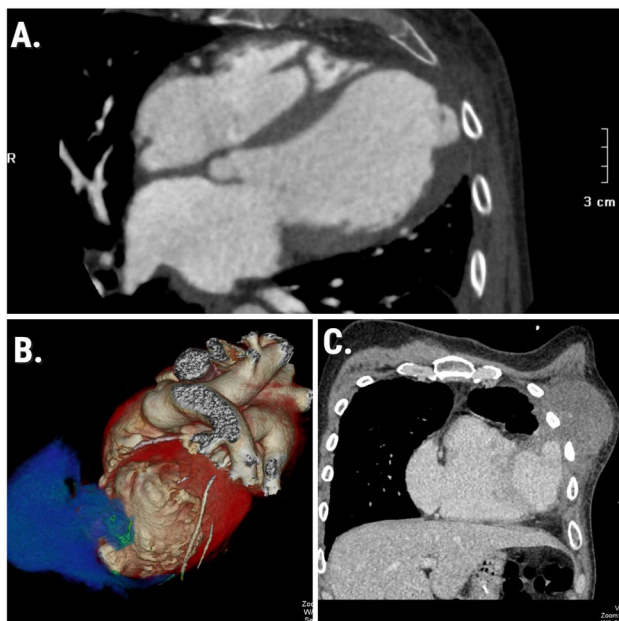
A 44-year-old man with a stab wound to the left chest. (A) Axial CT show pseudoaneurysm of the anterior wall of the left ventricle with signs of active extravasation of the contrast agent and occlusion of the LAD (see VR (B)). (C) Coronal CT shows a large hematoma of the left anterior chest wall, which is associated with pseudoaneurysm
